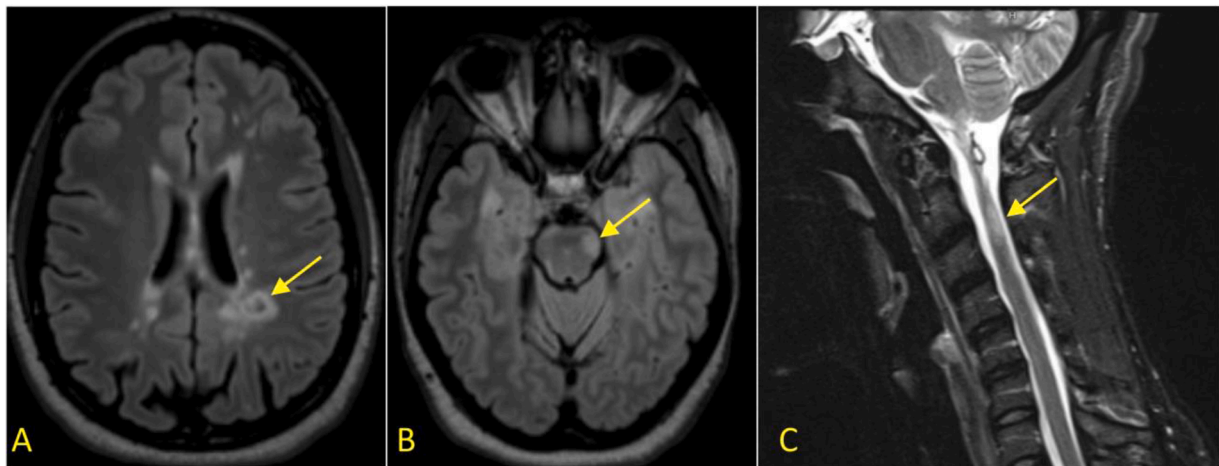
Representative MRI sequences demonstrating this 32-year-old female patient’s lesion burden. A. Axial T2 fluid-attenuation inversion recovery (FLAIR) sequence showing diffuse periventricular lesion burden, left parietal white matter lesion with central hypointensity (arrow), and diffuse atrophy. B. Axial T2 FLAIR sequence demonstrating hyperintense foci within the left pons (arrow). C. Sagittal T2 short tau inversion recovery (STIR) sequence demonstrating a hyperintense foci at the left C2-C3 hemicord (arrow).
